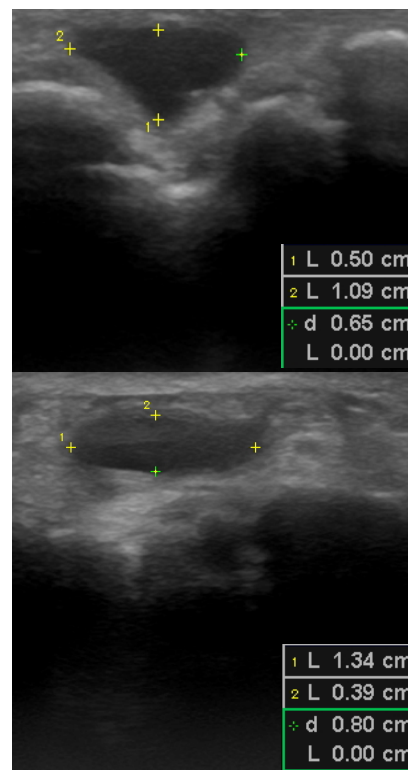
Observation of the dorsal ganglion cyst under ultrasonographic scan on the patient's wrist on Visit 2.
